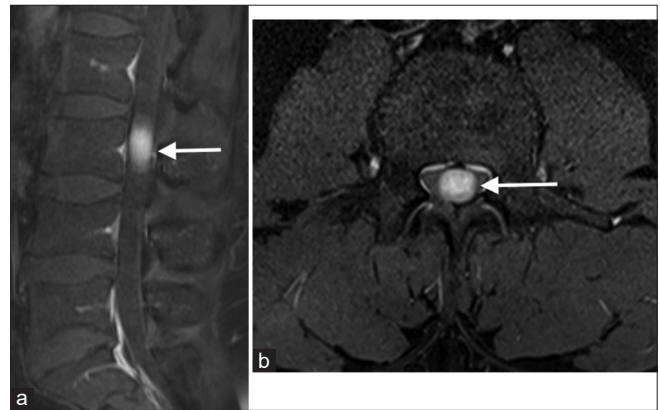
A sagittal (a) and axial (b) contrast-enhanced MRI image showing a homogenous contrast-enhancing lesion (as indicated by arrow).
